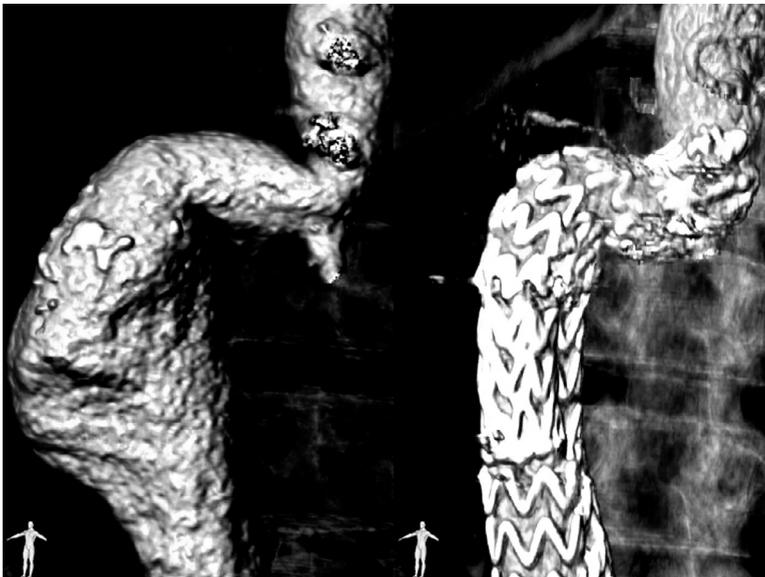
CTA 3-dimensional reconstruction of the abdominal aorta, pre- and post-implantation. Legend: Notice the adaptation of the endograft to the underlying anatomy without significant change in the shape of the vessel. The first covered stent lies parallel to the axis of the vessel.
